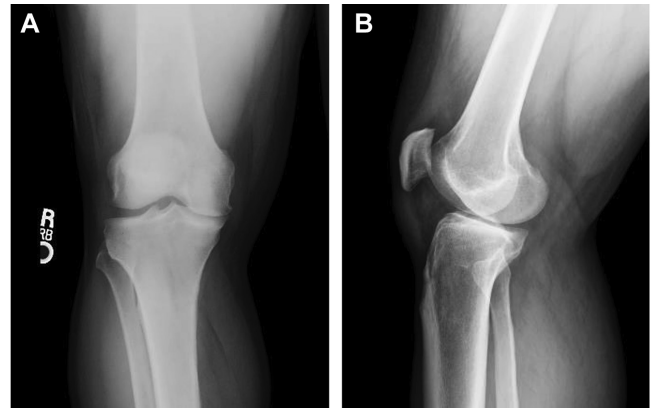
(A) Preoperative anteroposterior and (B) lateral knee radiographs demonstrating Kellgren-Lawrence grade 3 osteoarthritis characterized by moderate osteophytes, definitive joint space narrowing, and subchondral sclerosis of the medial tibial plateau.
